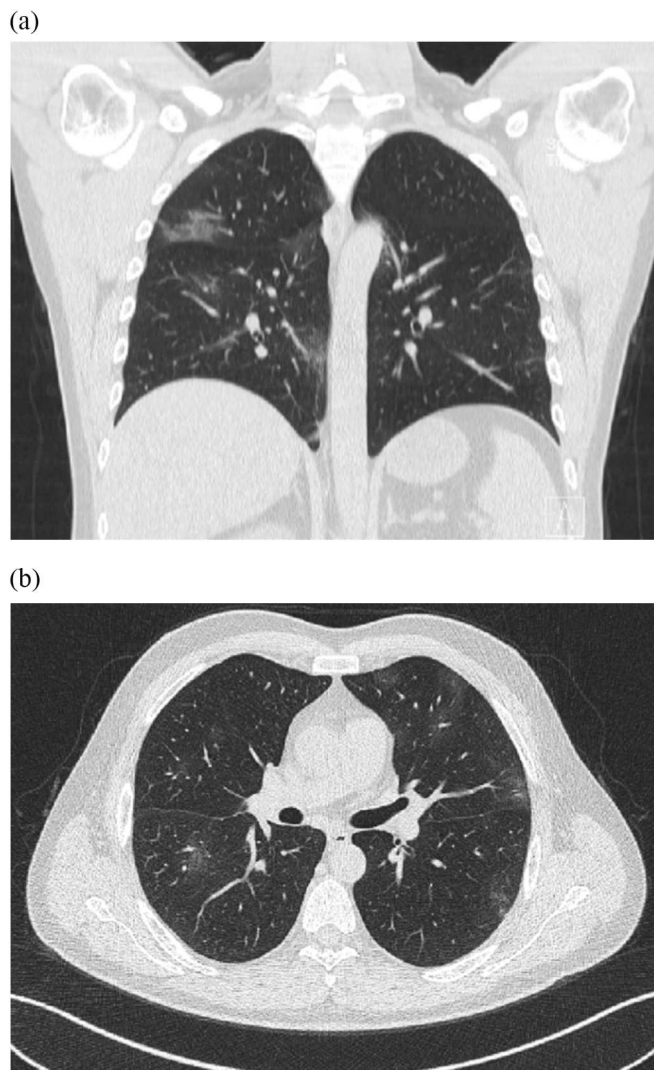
Torax CT showed multiple, dominantly right patchy, peripheral, ground-glass opacities in both lungs a) coronal, b) Axial images.
